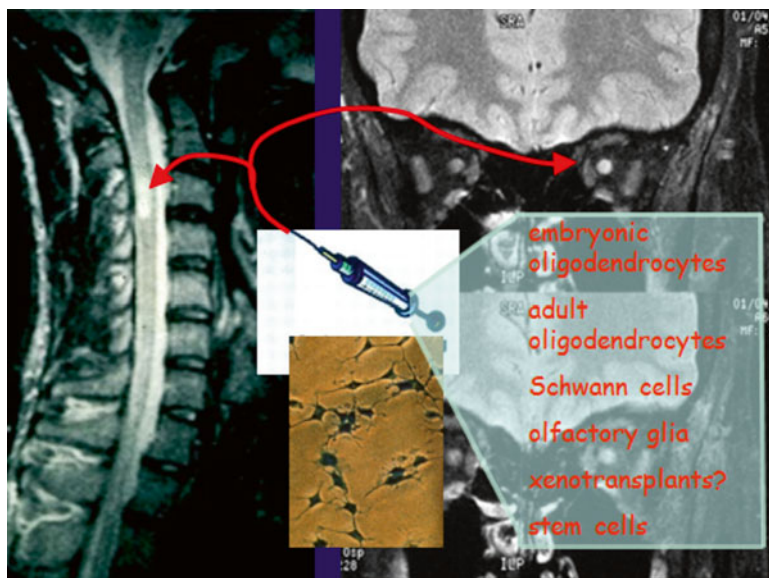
The “classical” approach to cell therapy in MS—the direct injection of cells capable of producing myelin into MS lesions shown by MRI scanning
